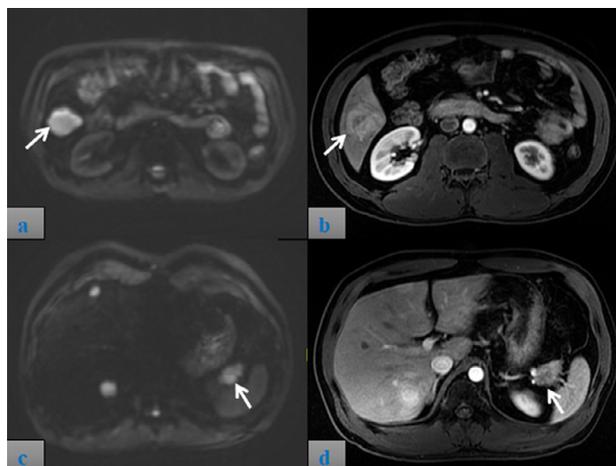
Magnetic resonance imaging (MRI). (A) Diffusion-weighted imaging (DWI) sequence: hyperintensity of the hepatic lesion signal at segment VI (arrow). (B) Arterial phase: heterogeneously strong enhancing (arrow). (C) DWI sequence: signal hyperintensity of the pancreatic tail lesion (arrow), which is similar to the presentation of hepatic lesions. (D) Arterial phase: poorly enhancing pancreatic tail lesion compared with the remaining pancreatic parenchyma (arrow).
